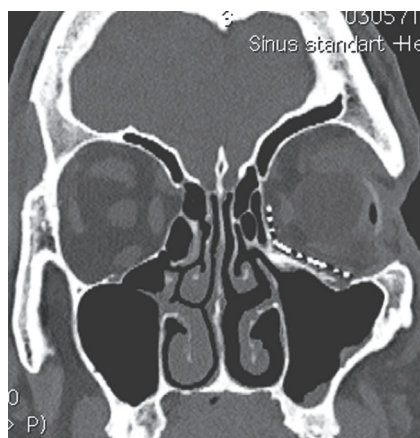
Multispiral computed tomography. Frontal view. Two years after surgery. Titanium mesh over the zone of the defect. Spherical implant and external cosmetic prosthesis in the orbital cavity
